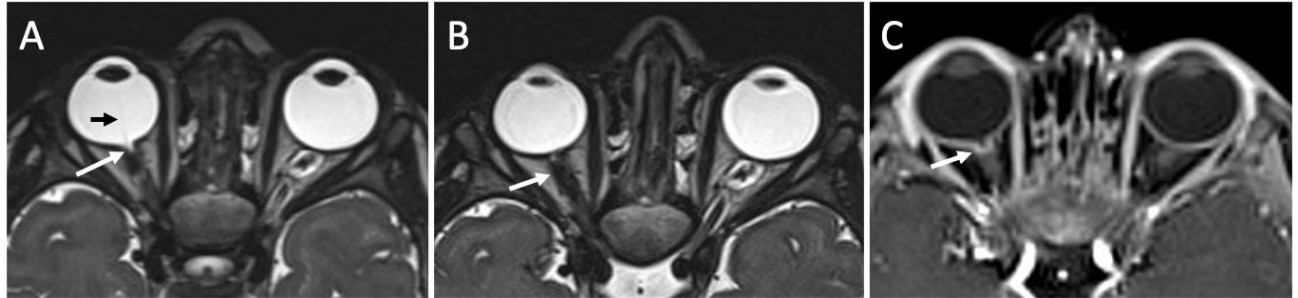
(a) Axial T2-sampling perfection with application optimized contrasts using different flip angle evolutions (SPACE) image shows funnel-shaped excavation of the right optic disc associated with elevated adjacent retinal surface and discontinuity of the uveoscleral surface (white arrow). A thin and faint band of tissue extending from the posterior surface of the lens to the head of the optic nerve along the Cloquet canal (black arrow). (b) Axial T2-SPACE image demonstrates effacement of the fluid signal in the right optic nerve sheath around the right optic nerve (arrow). (c) Axial contrast-enhanced T1-weighted image with fat saturations shows marginal enhancement of the distal right optic nerve (arrow).
